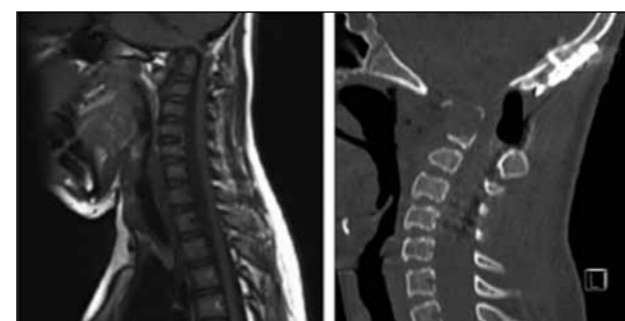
A) Sagittal T1 MRI demonstrating a very significant craniocervical stenosis. B) Post operative sagittal CT scan following transnasal endoscopic resection of the odontoid peg with external cervical fixation. The defect in the nasopharynx was filled with fat from the abdomen.
